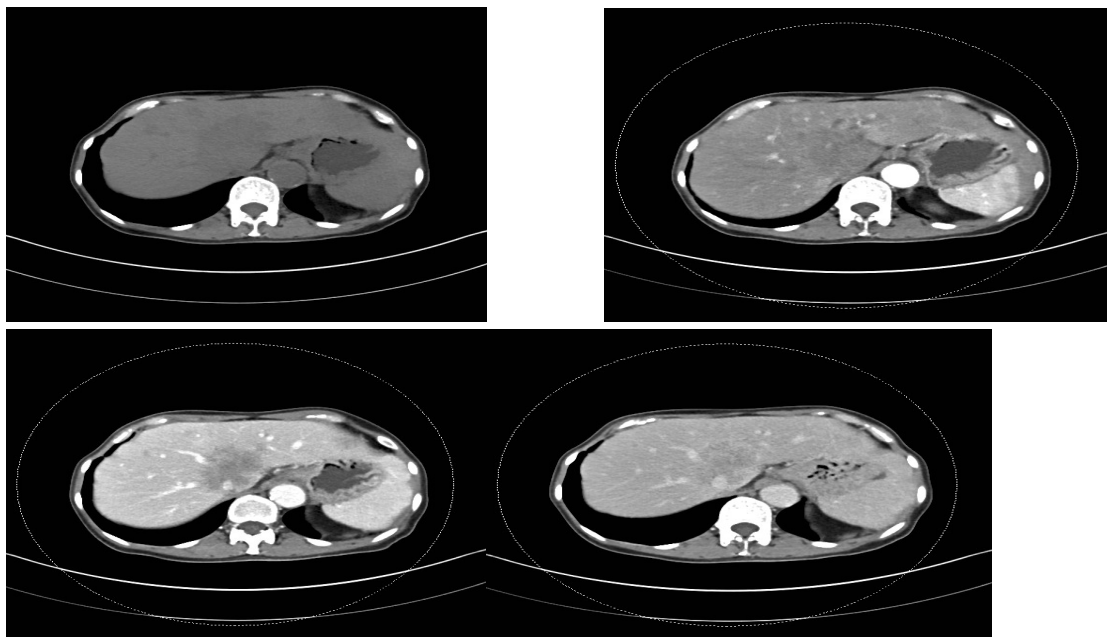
Abdominal CT with and without contrast showing irregular hypodense masses around the hilum.
